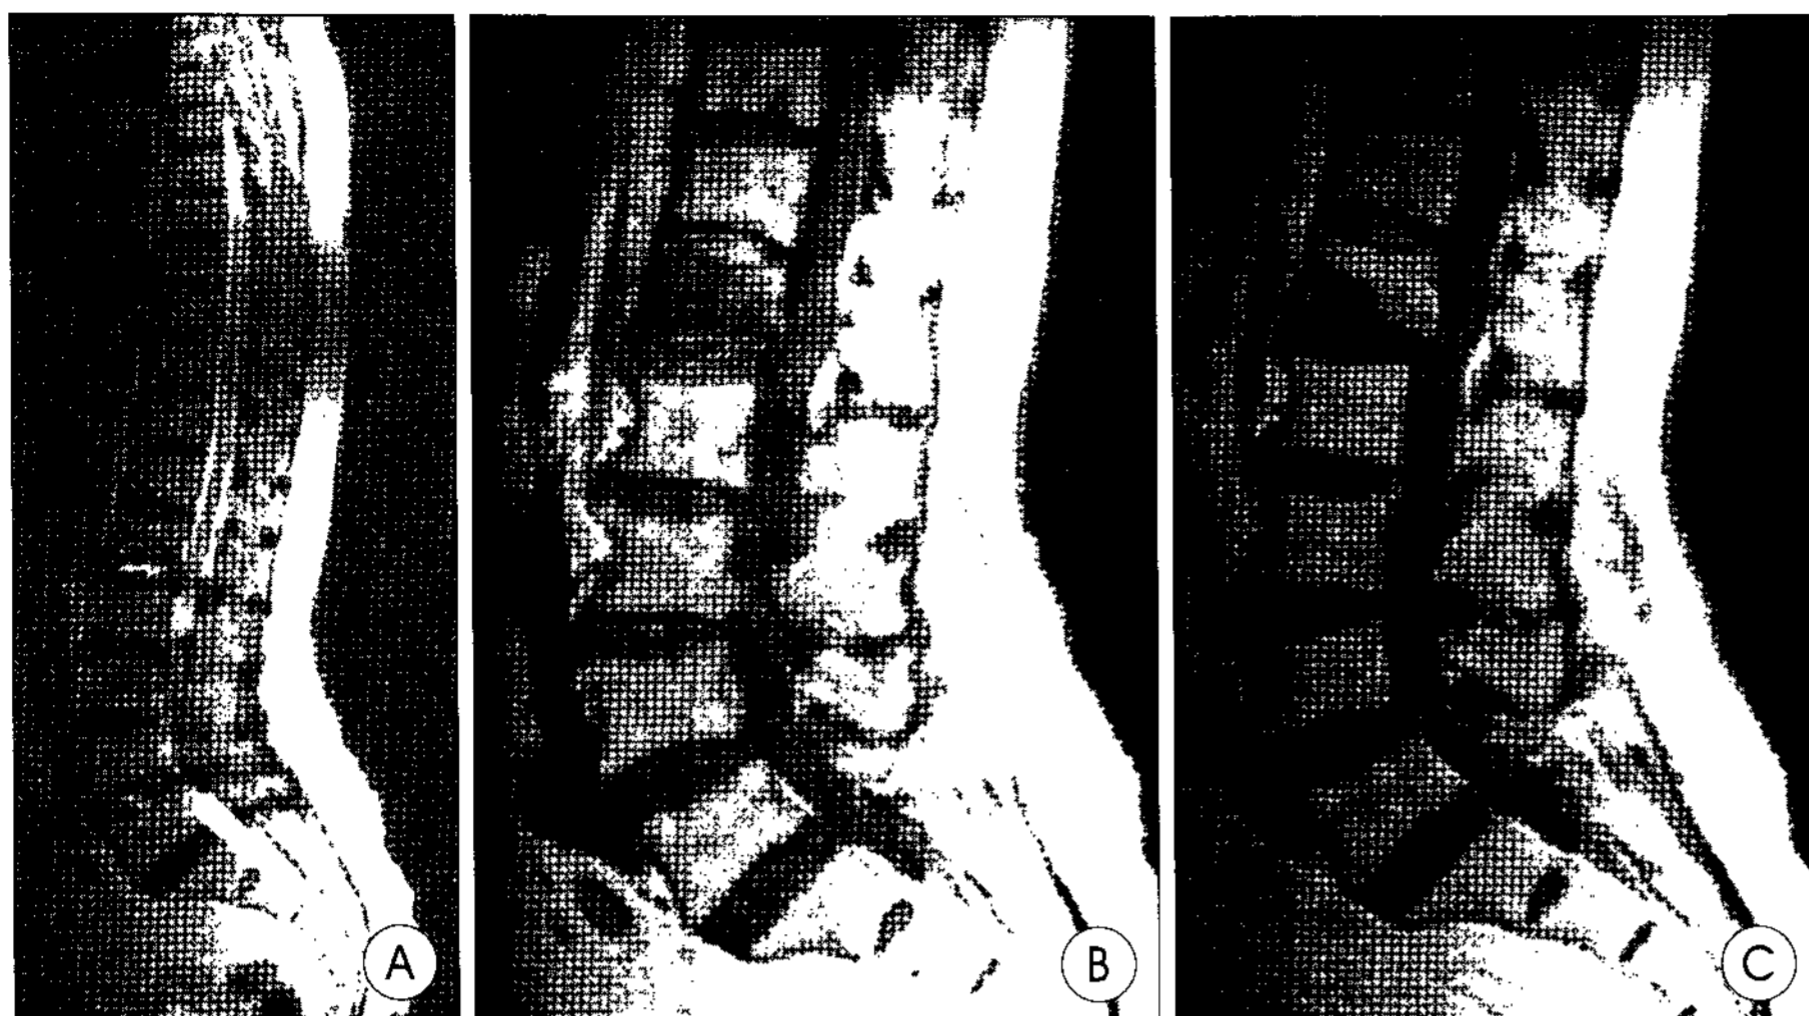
A 89-year-old woman is admitted to our hospital with low back pain and right side sciatic pain for 1 month. A : T2 weighted magnetic resonance image of lumbar spine showing unusual bright signal intensity change of L1/2 and L4/5 disc space. B : T1 weighted magnetic resonance image revealing low signal intensity of L1 vertebral body. C : This lesion is not enhanced with gadolinium enhanced magnetic resonance image.
